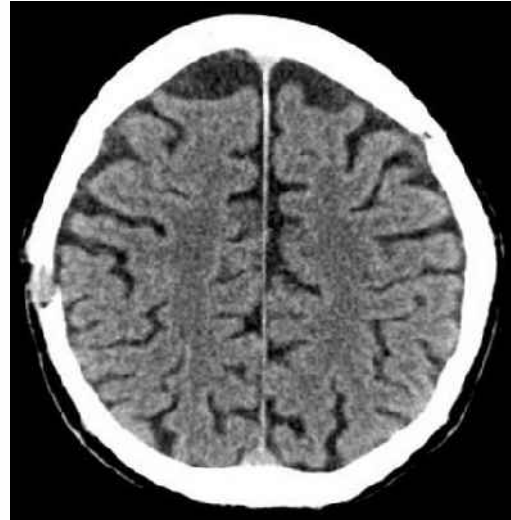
Axial CT image of the brain at four months postoperation shows early osteogenesis of the burr hole.
